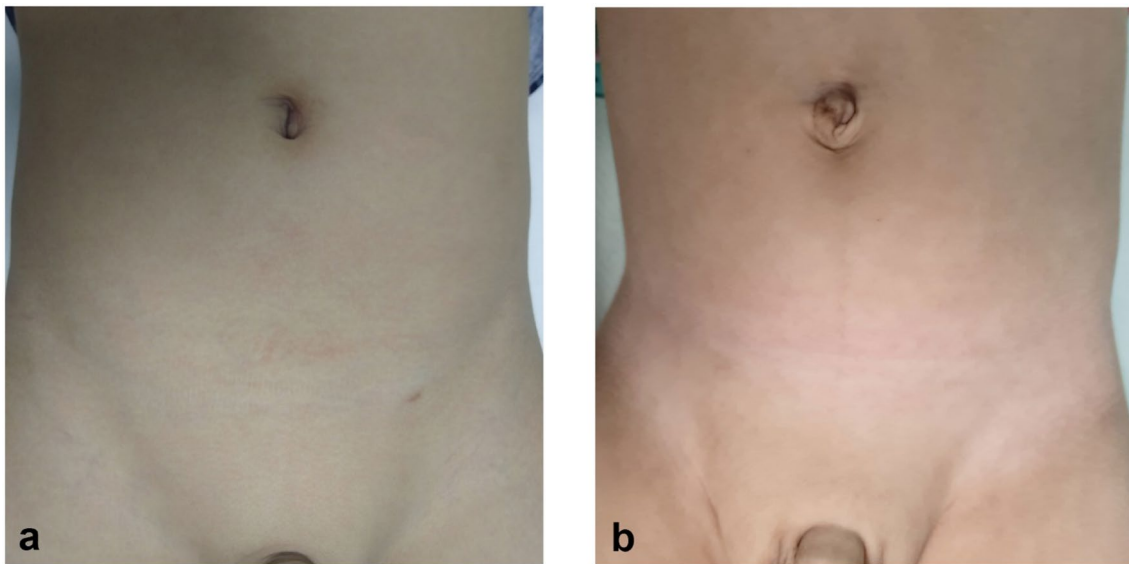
Cosmetic results after FLAIR. a Two-year-old boy after Left FLAIR (CAT2). Barely visible scar after 6 weeks. b Seven-month-old boy after bilateral FLAIR (CAT1). There are no visible scars after 5 months
